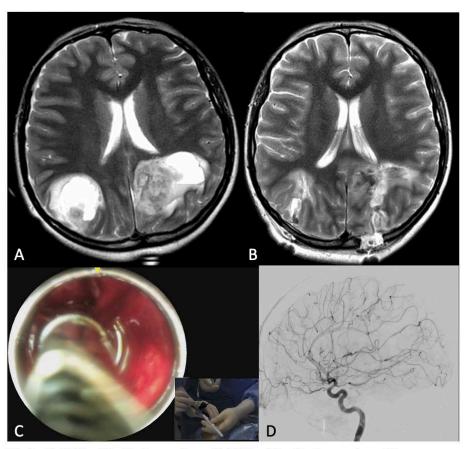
A) MRI of PreOp hemorrhage B) MRI of PostOp hemorrhage C) Surgiscopic view of the hematoma with the Aurora Evacuator. The picture-in-picture shows monopolar cautery applied to the proximal shaft of the evacuator. D) Sagittal view of internal carotid artery (ICA) vasculitis
